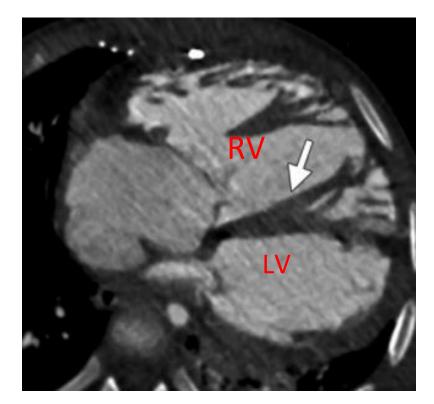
CT axial image shows in morphological right ventricle, the trabeculae are coarse and the papillary muscles attach to both free wall and interventricular septum. It contains "moderator band" (white arrow), a thick trabecular structure extending from anterior papillary muscle to interventricular septum (D- Loop)
